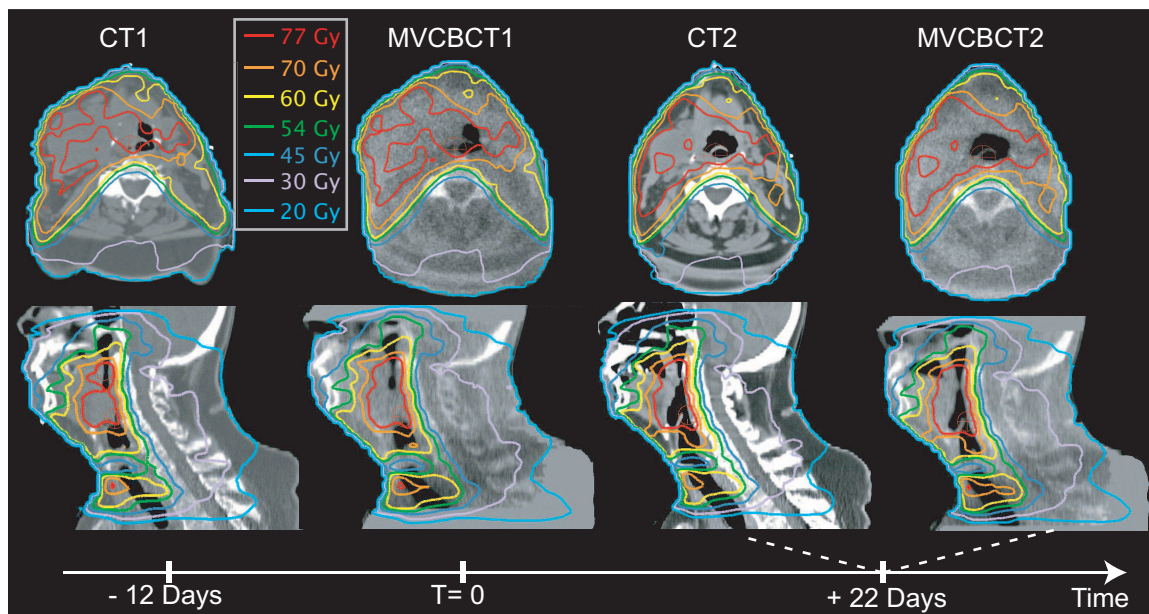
Dose calculation on a patient treated for a base of tongue tumor with IMRT. The initial plan defined on the initial CT (CT1) was applied on a MVCBCT acquired in the first week of treatment (MVCBCT1) and additional CT (CT2) and MVCBCT (MVCBCT2) acquired 22 days after the beginning of therapy. Axial and sagittal images crossing the isocenter show good qualitative agreement between the isodose lines (CT1 with MVCBCT1 and CT2 with MVCBCT2).
